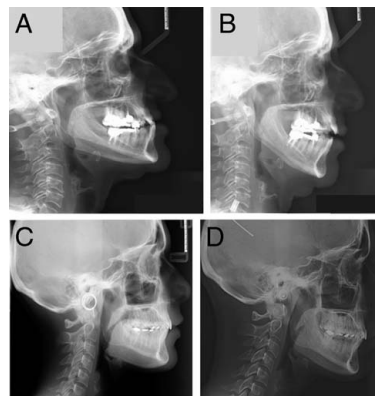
Lateral radiographs of 2 patients before and after condylectomy. The discrepancy of the mandibular lower border improved by 5 mm in both patients; however, although the patient in Figures A and B reached almost normal relations between right and left mandibular lower borders, the patient in C and D continued to suffer from a noticeable asymmetry in this area. Notice the slight mandibular setback with clockwise rotation occurring in both patients after condylectomy.
